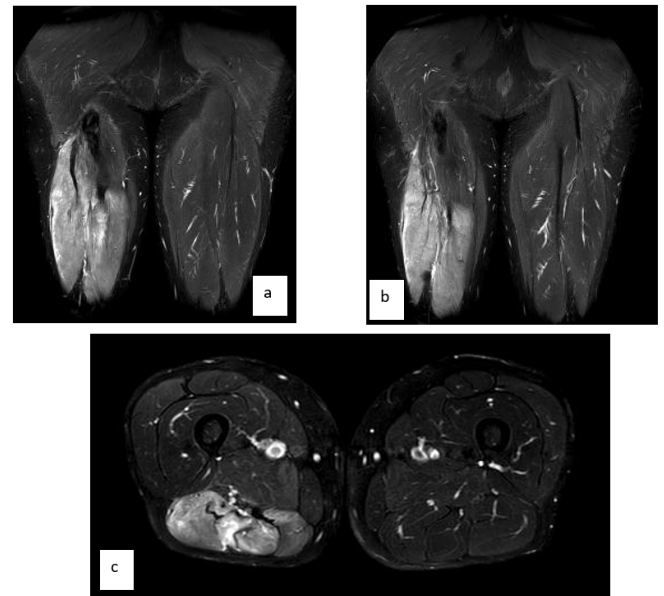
(a-b) Coronal T2-weighted fat-suppressed MRI demonstrating proximal avulsion of the biceps femoris and semitendinosus tendons with associated edema and hematoma in the posterior thigh, as well as asymmetry compared to the contralateral side. (c) Axial T2-weighted fat-suppressed MRI with edema in the posterior right thigh.
